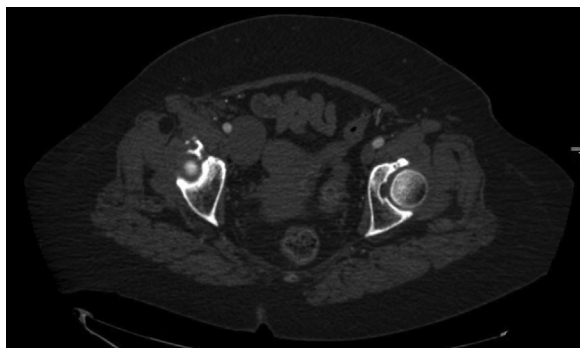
Computed tomography venogram showing 4.3 cm × 3.4 cm × 5.6 cm right external iliac vein aneurysm.
